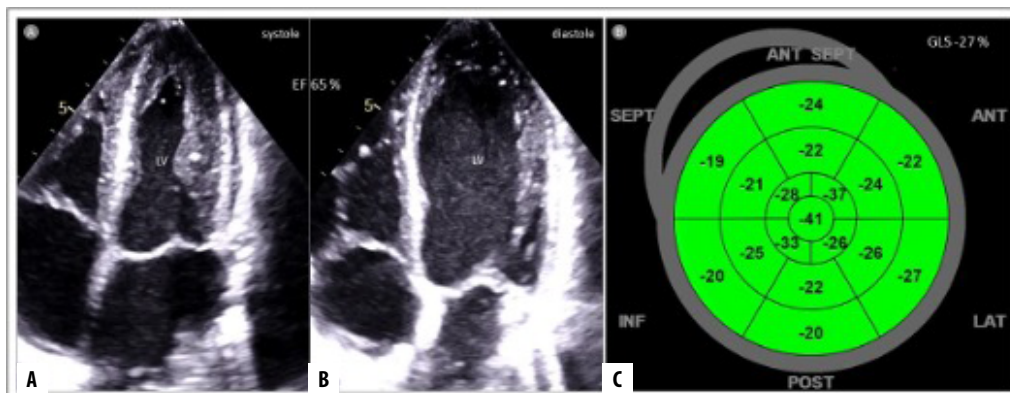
Two-dimensional echocardiography in apical four-chambers view: normal left ventricular function with ejection fraction (EF) 65% (A) and global longitudinal strain (GLS) -27% (B); see high regional LS in apical segments (C).
